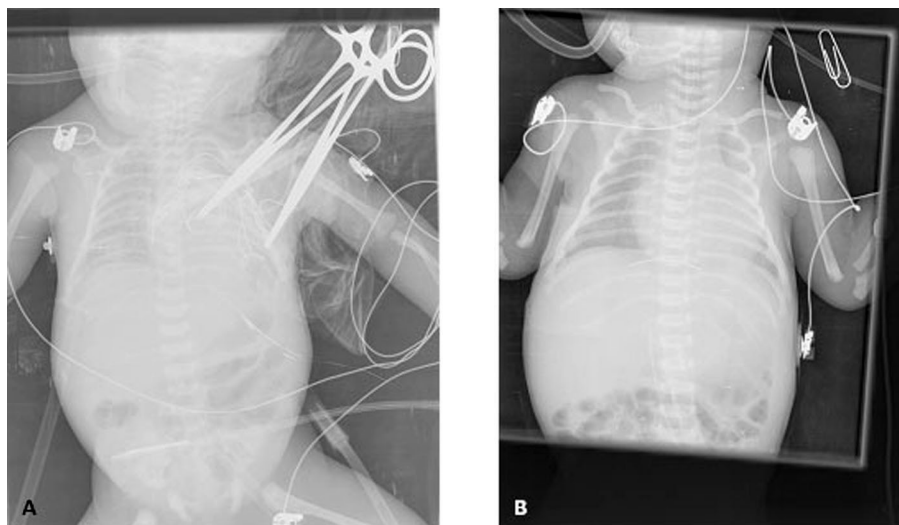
A: Anteroposterior chest X-ray (POD1 after ECMO initiation). B: Anteroposterior chest X-ray (POD6 after ECMO discontinuation)
